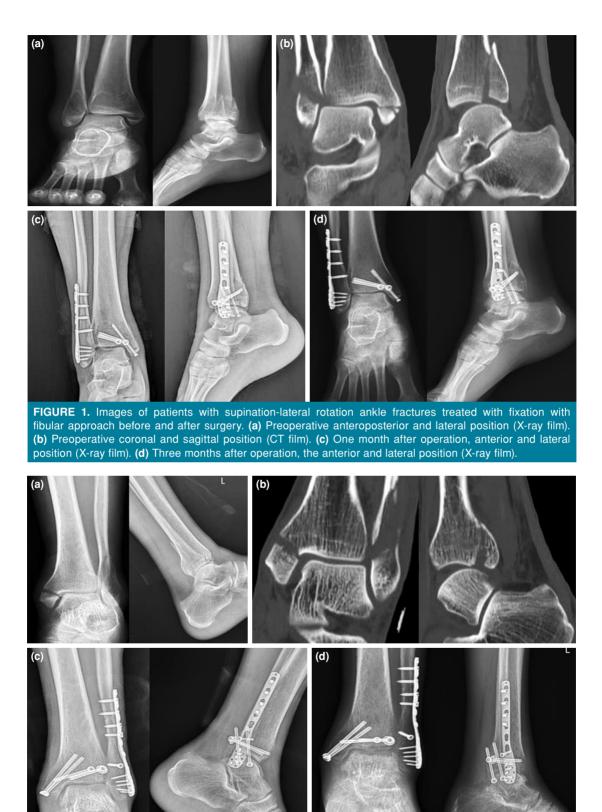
Images of patients with supination-lateral rotation ankle fractures treated with fixation with posterolateral fibular approach before and after surgery. (a) Preoperative anteroposterior and lateral position (X-ray film). (b) Preoperative coronal and sagittal phosition (CT film). (c) One month after operation, anterior and lateral position (X-ray film). (d) Three months after operation, the anterior and lateral position (X-ray film).
